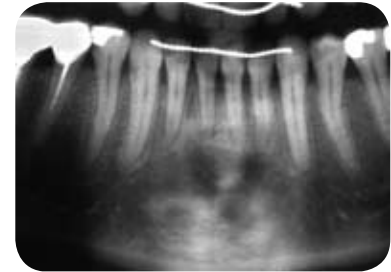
Periapical radiographs at the end of treatment showing the augmentation of bone in the lower anterior region and the optimal conditions for papillas reconstruction.
